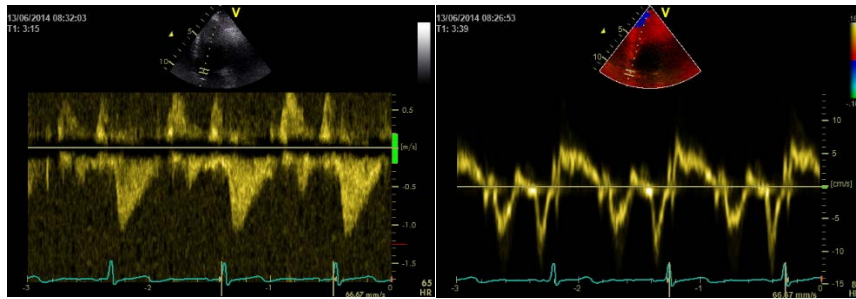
Doppler echocardiograms. Aortic outflow velocity (right) and septal wall velocity (left)
